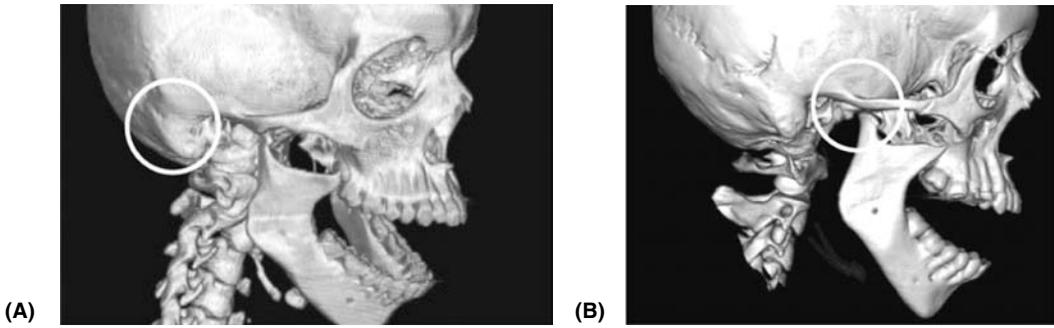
Computed tomography scan demonstrating (A) before and (B) after eminectomy in a patient with chronic temporomandibular joint dislocation and locking. Procedure relieved symptoms.
